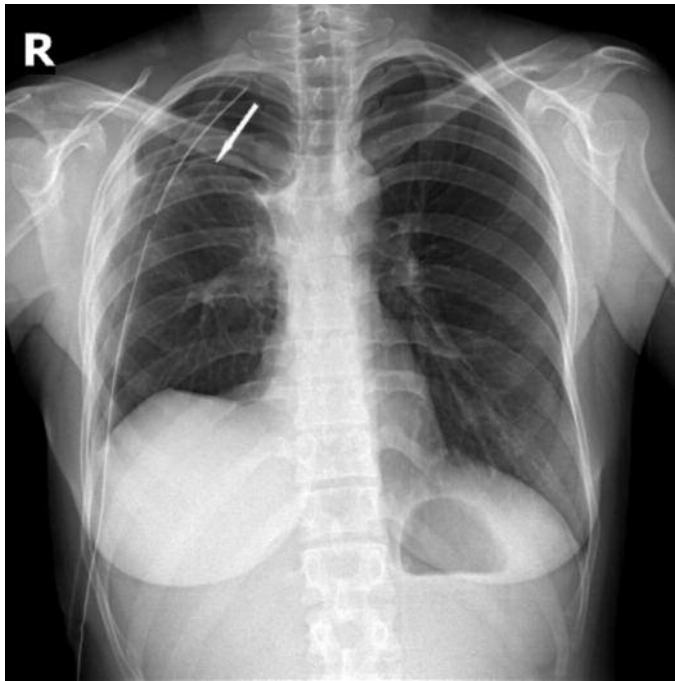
Chest X-ray before the attachment Heimlich valve. White arrow shows visceral pleural surface.
